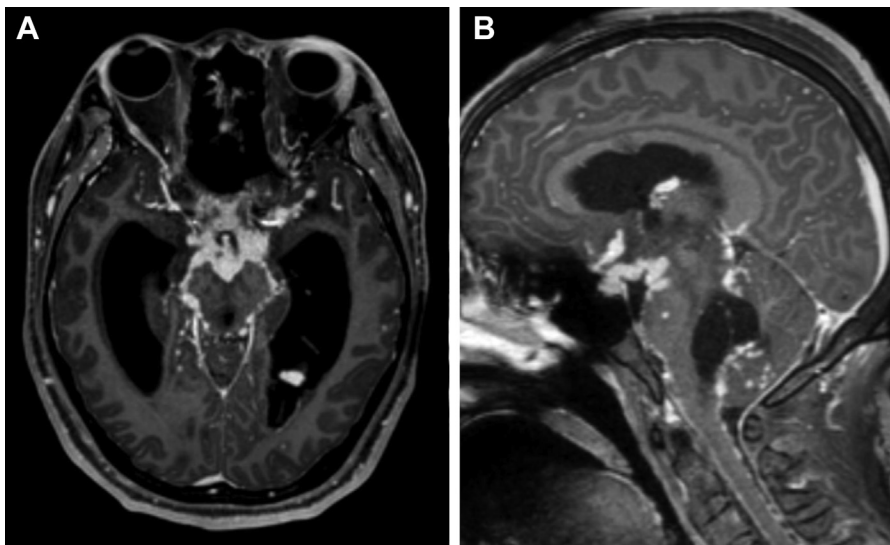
Tuberculous ventriculitis and meningitis. Axial T1-weighted postcontrast MR imaging shows diffuse extensive thick enhancement of the basal cisterns that extends to the occipital horn of the left lateral ventricle and secondary hydrocephalus (A). Sagittal T1-weighted postcontrast MR imaging shows involvement of the suprasellar cistern, inferior ependymal lining of the fourth ventricle, and dorsal surface of the upper cervical spinal cord (B).
